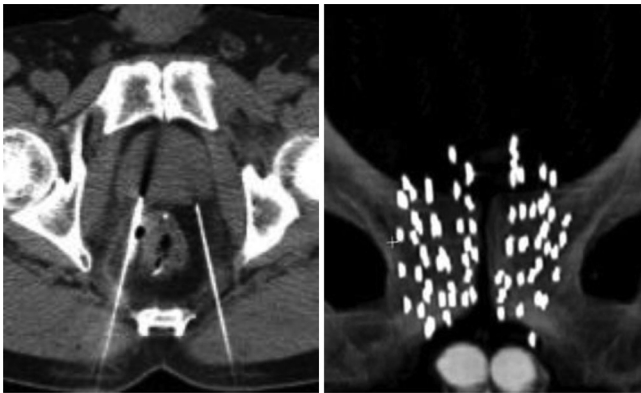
CT-guided interventional procedures on the prostate. (Left) Two needles inserted bilaterally performing transgluteal prostate biopsy [11], [12]. (Right) Multi-adjacent seeds closely implanted within the prostate gland [13].
